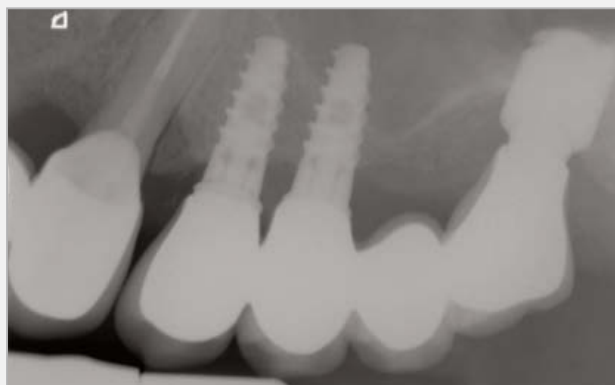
Case 2 - X-ray at 6 months with final restoration in place.
